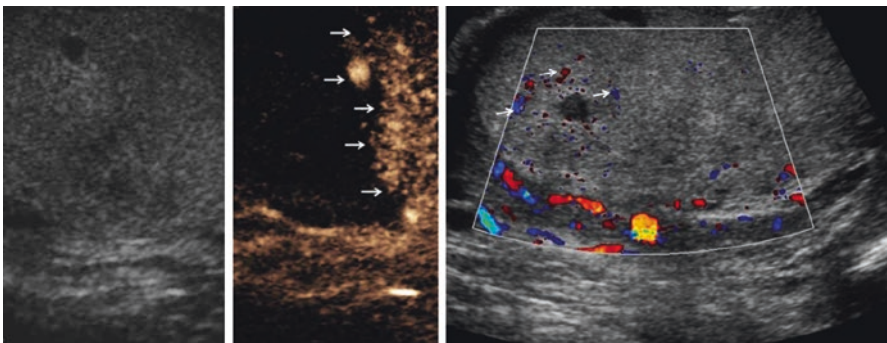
Longitudinal ultrasound image of the right testis. The right testis with microbubble contrast imaging, 24 s after administration of SonoVue™ (Bracco SpA, Milan, Italy), demonstrating a clear demarcation between vascularised and non-vascularised tissue (*arrows*)
